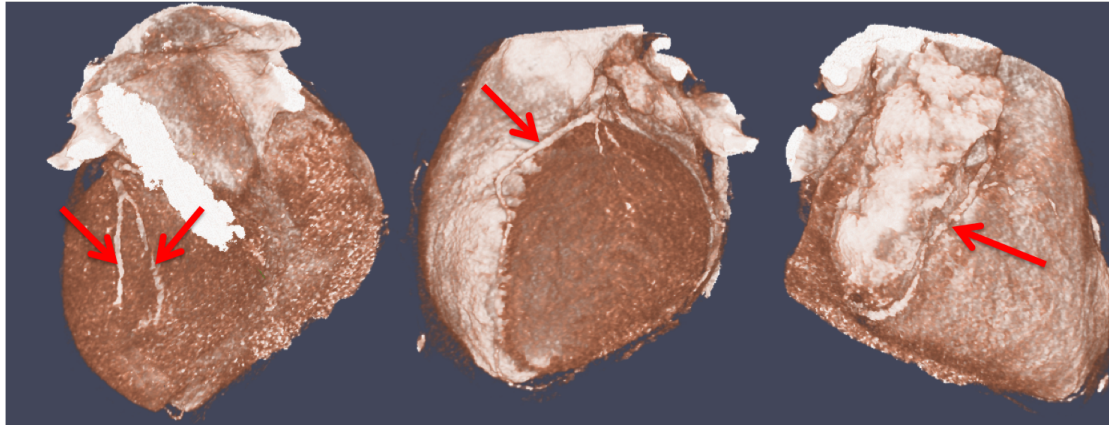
Volume rendering of CTA image in the end-diastolic time frame from one patient dataset. From left to right, left circumflex artery and branches (LCX), left anterior descending artery and a diagonal branch (LAD) and right coronary artery (RCA) are visible and indicated by the red arrows.
